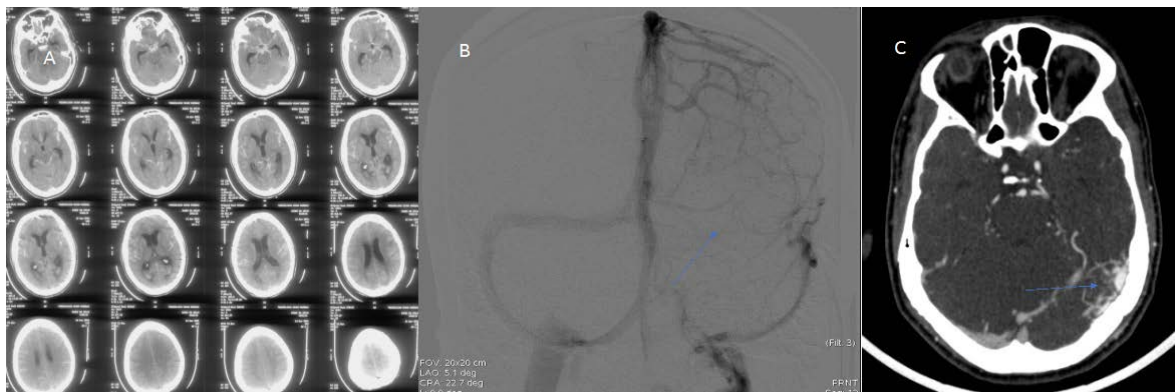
A shows axial cuts of plain CT with diffuse SAH and hydrocephalus, B showing initial DSA venous phase showing left hypo plastic transverse and sigmoid sinuses; C shows follow up CT angiography axial cut showing dural AVF at left TS-SS junction (arrow)
